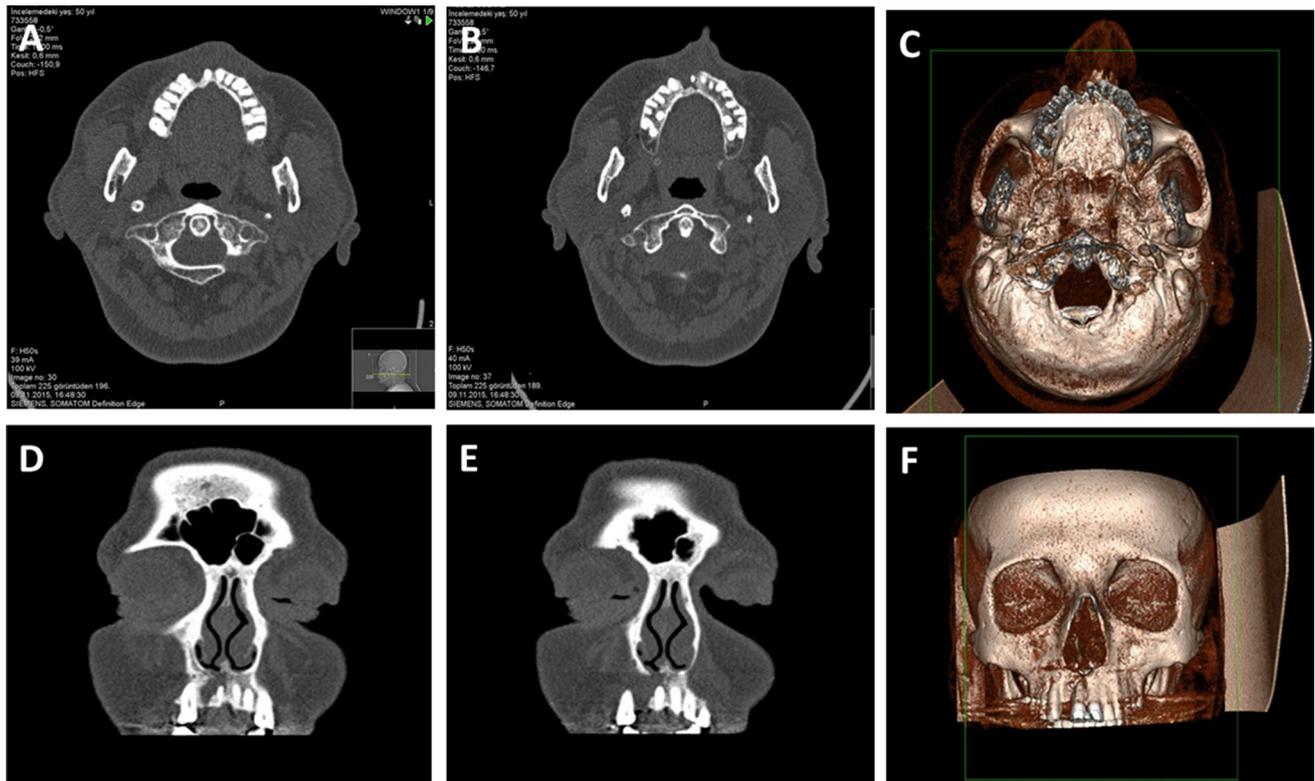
Preoperative maxillofacial computed tomography view a, b axial plane, c 3-D axial plane, d, e coronal plane, f 3-D coronal plane
